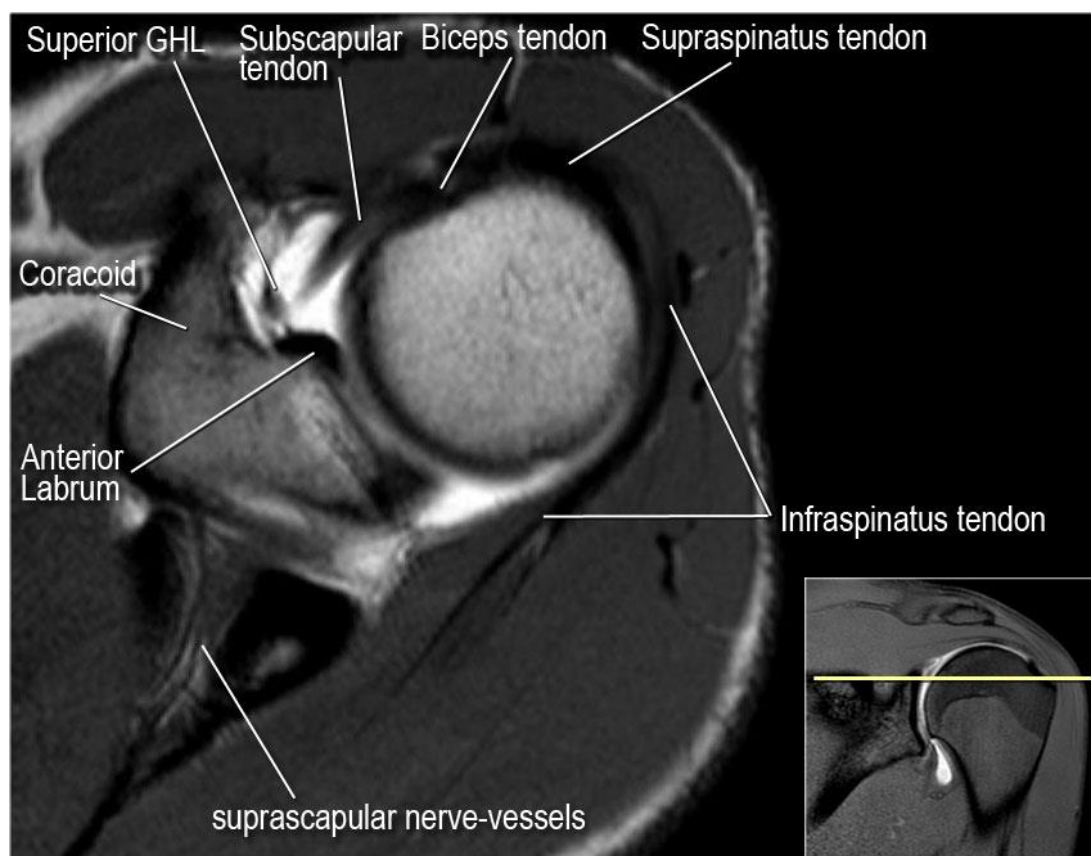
Axial view T2 weighted MRI of the shoulder showing the SGHL.
